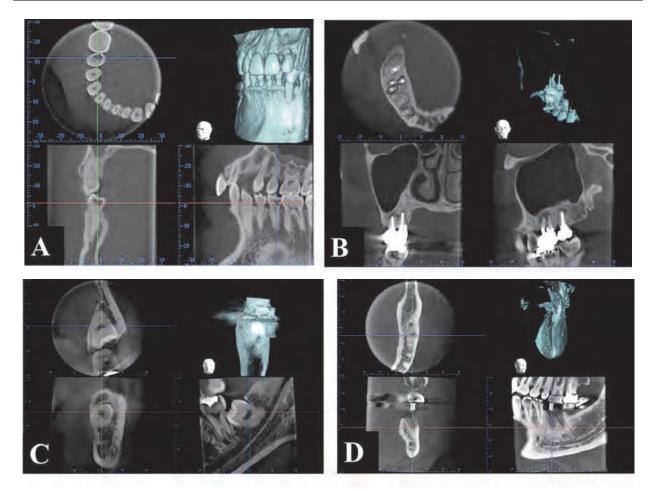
CBCT images of dental caries in the right second premolar (A). CBCT images of marginal and/or periapical periodontitis in the maxillary molar region (B). CBCT images of an impacted tooth in the mandibular third molar region (C). CBCT images of the evaluation before dental implant surgery in the mandibular molar region (D).
